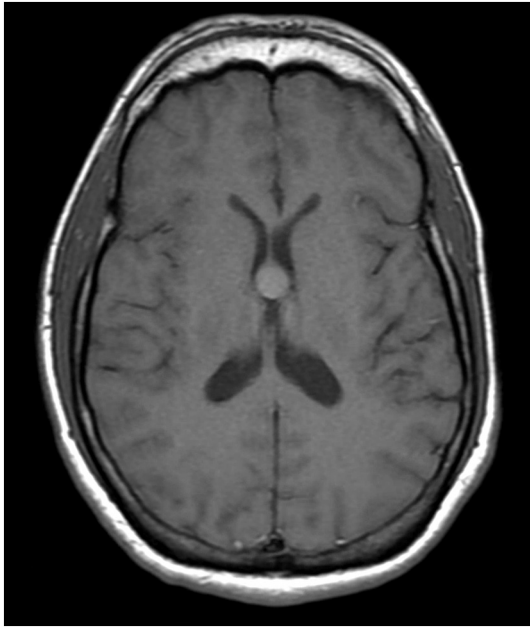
MRI colloid cyst - axial T1 sequence.
